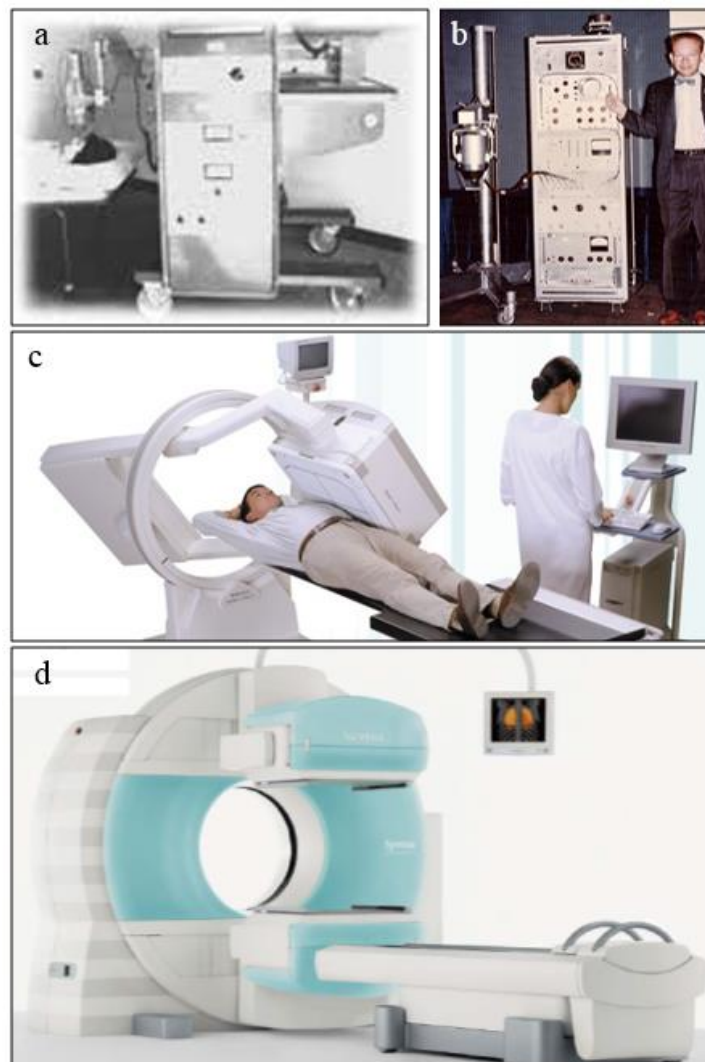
The evolution of gamma camera technologies from early (a) rectilinear scanner "Picker Magna Scanner" [12], (b) Anger camera [12], single-head LFOV gamma camera [13] to state-of-art SPECT-CT imaging system [3].
